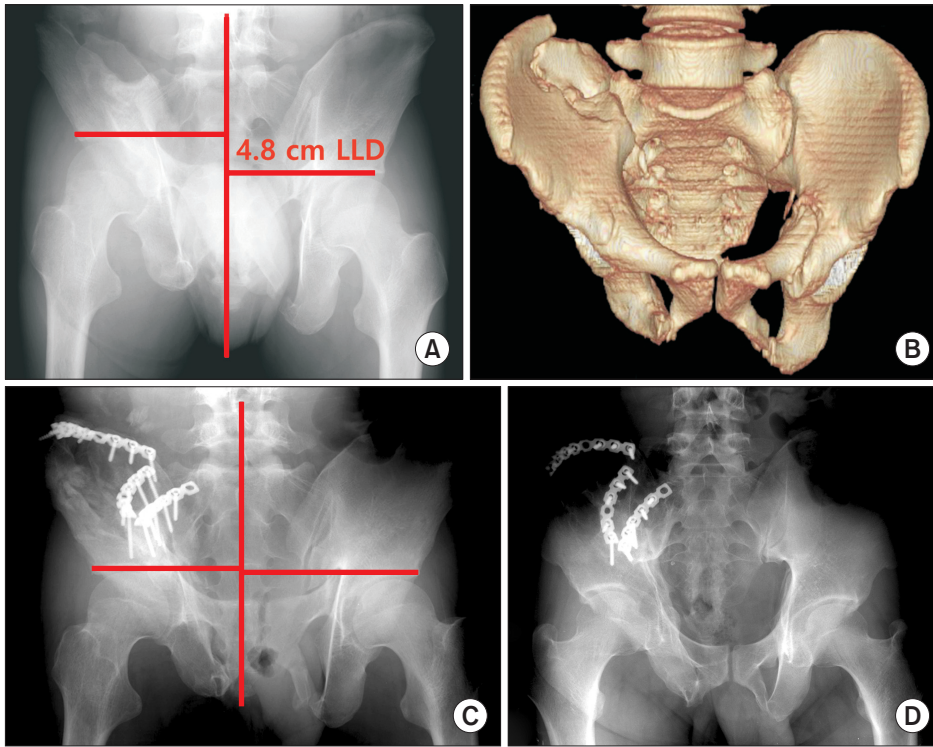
Case 2. (A) The initial outlet view shows cranial displacement. LLD: leg-length discrepancy. (B) The three-dimensional computed tomography outlet view shows upward migration and medial translation deformity of the right hemipelvis. (C) The outlet view radiograph obtained immediately after surgery, shows correction of superior migration. (D) The radiograph obtained 2.7 years after surgery shows a well-maintained reduction.
